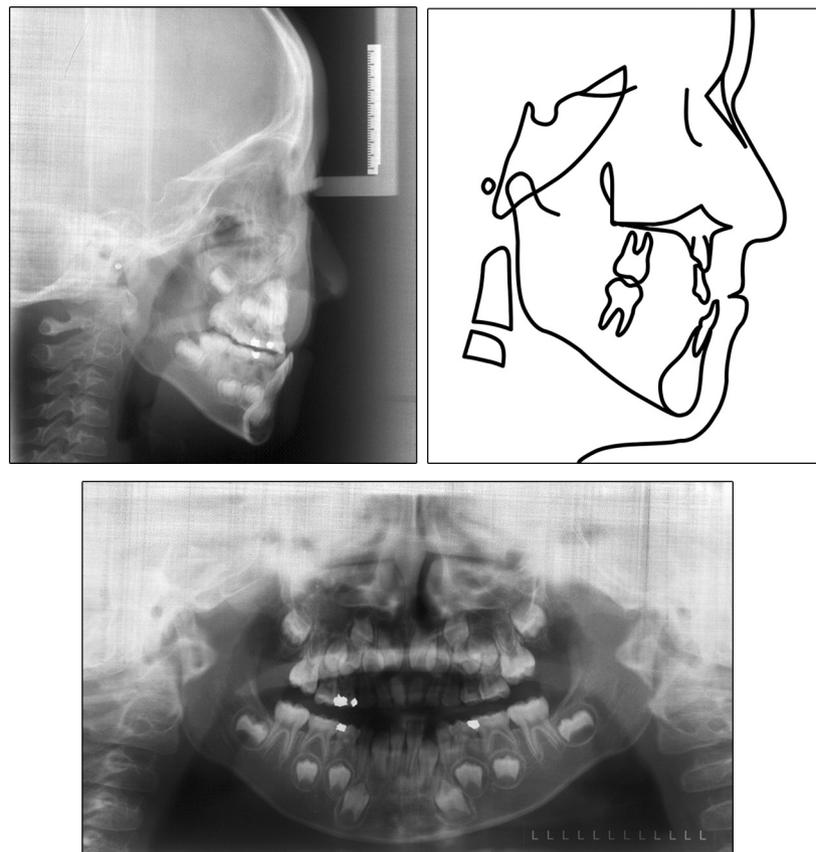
Pretreatment lateral cephalogram and tracing and panoramic radiograph.
